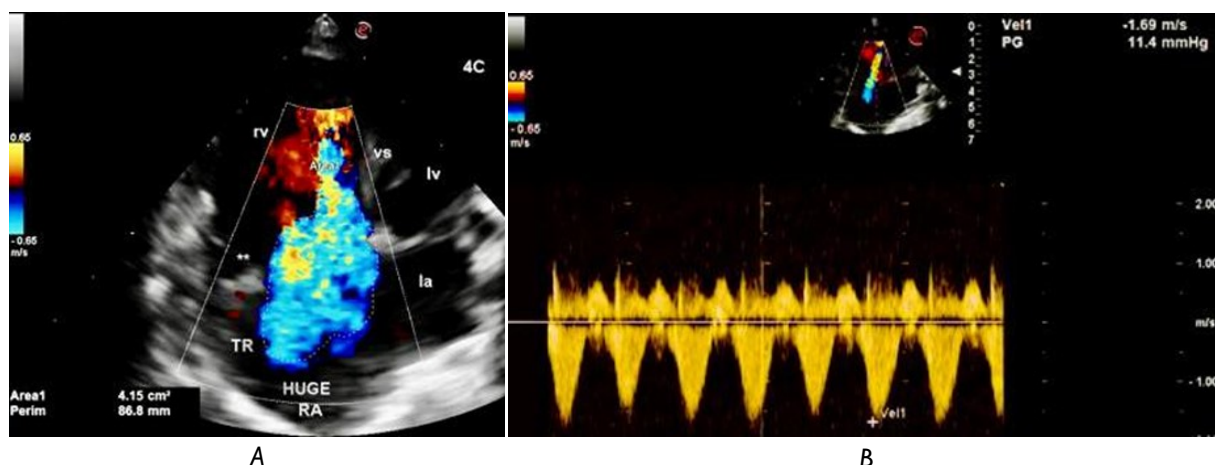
(A) 4CH view . On color flow mapping a severe tricuspid regurgitation (TR) jet is visualised. (B) On continuous wave Doppler analysis across TV, a low velocity signal of TR jet is delineated(TR velocity 1.69 m/sec).
